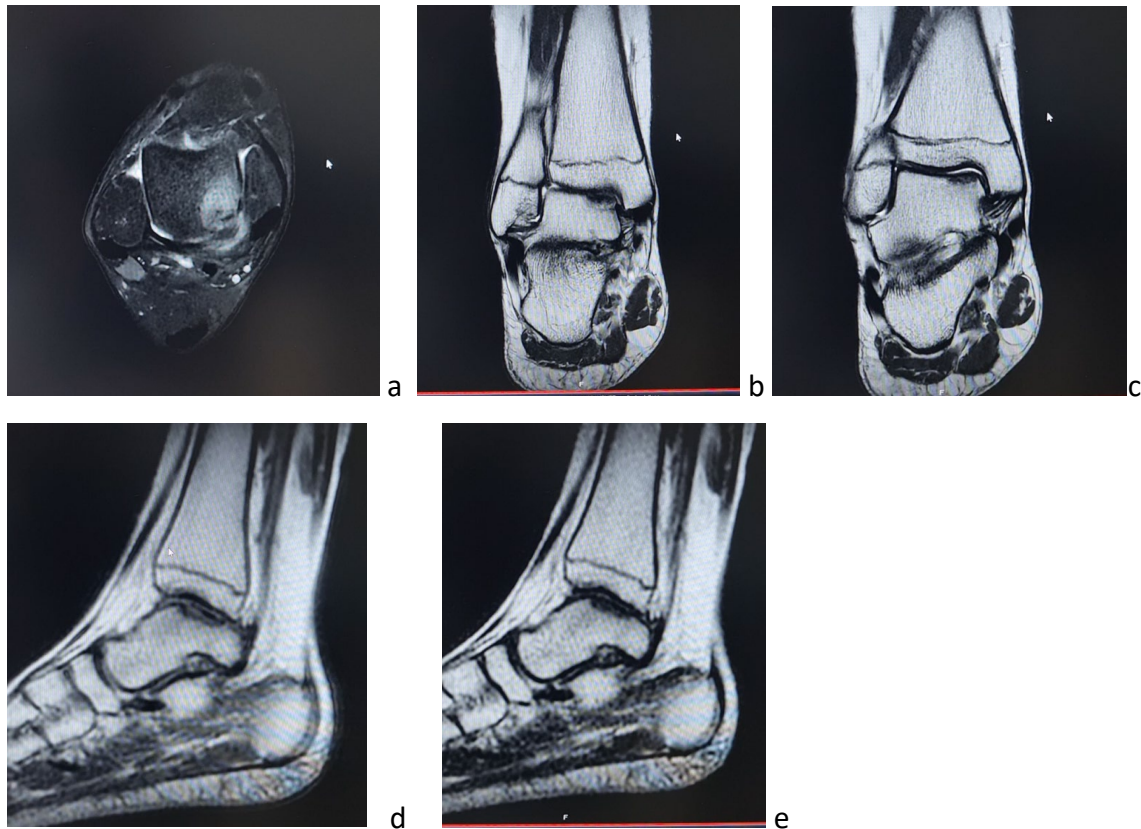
MRI. 31.a coronal view, 31.b-c frontal view, 31 d-e lateral view
